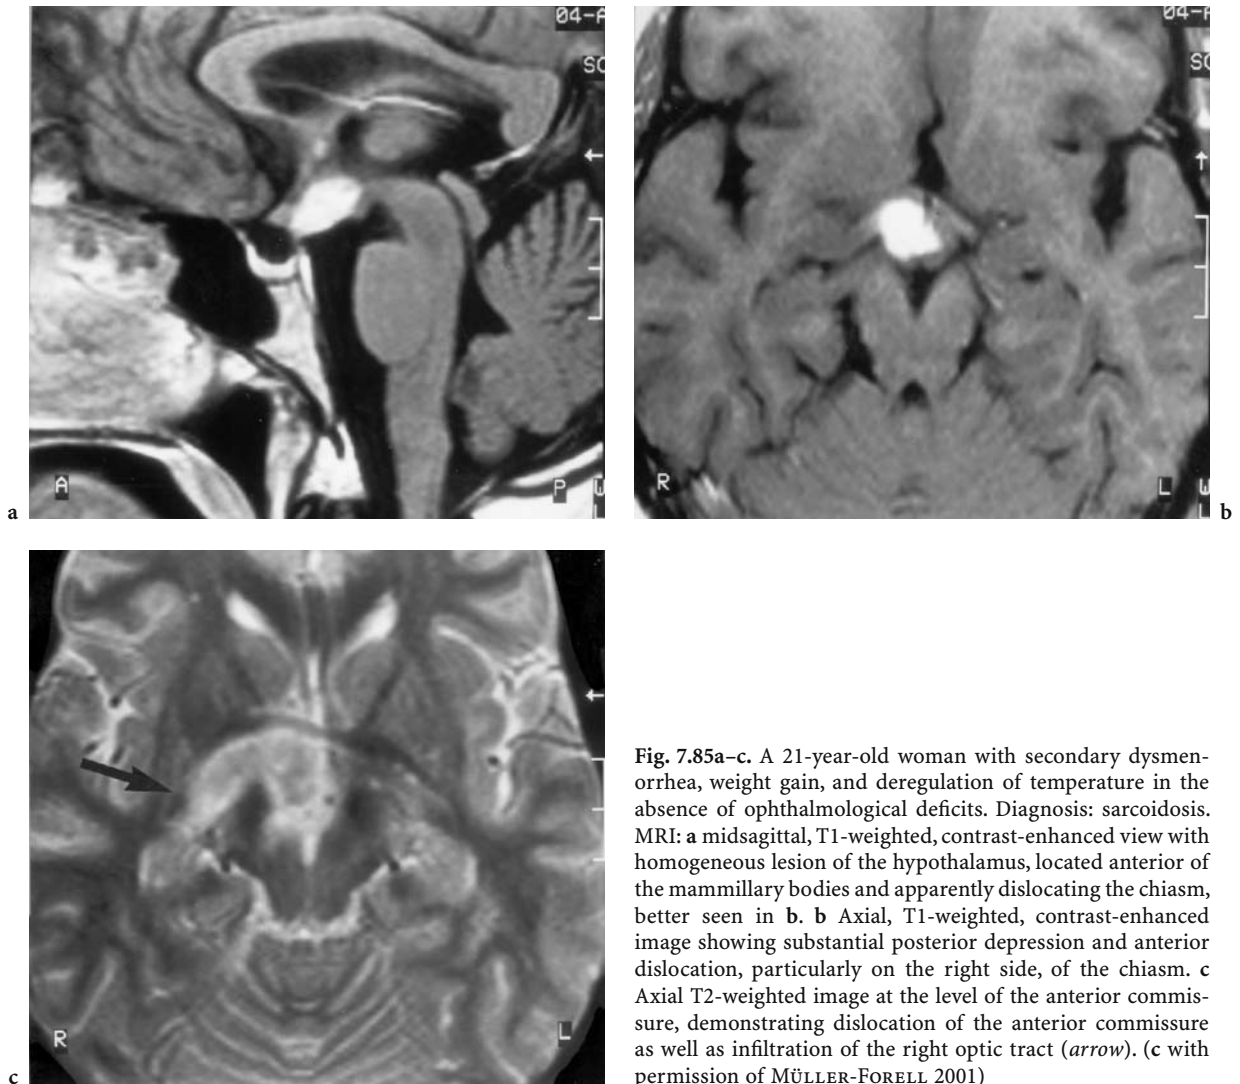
A 21-year-old woman with secondary dysmenorrhea, weight gain, and deregulation of temperature in the absence of ophthalmological deficits. Diagnosis: sarcoidosis. MRI: a midsagittal, T1-weighted, contrast-enhanced view with homogeneous lesion of the hypothalamus, located anterior of the mammillary bodies and apparently dislocating the chiasm, better seen in b. b Axial, T1-weighted, contrast-enhanced image showing substantial posterior depression and anterior dislocation, particularly on the right side, of the chiasm. c Axial T2-weighted image at the level of the anterior commissure, demonstrating dislocation of the anterior commissure as well as infiltration of the right optic tract (*arrow*). (c with permission of MÜLLER-FORELL 2001)
